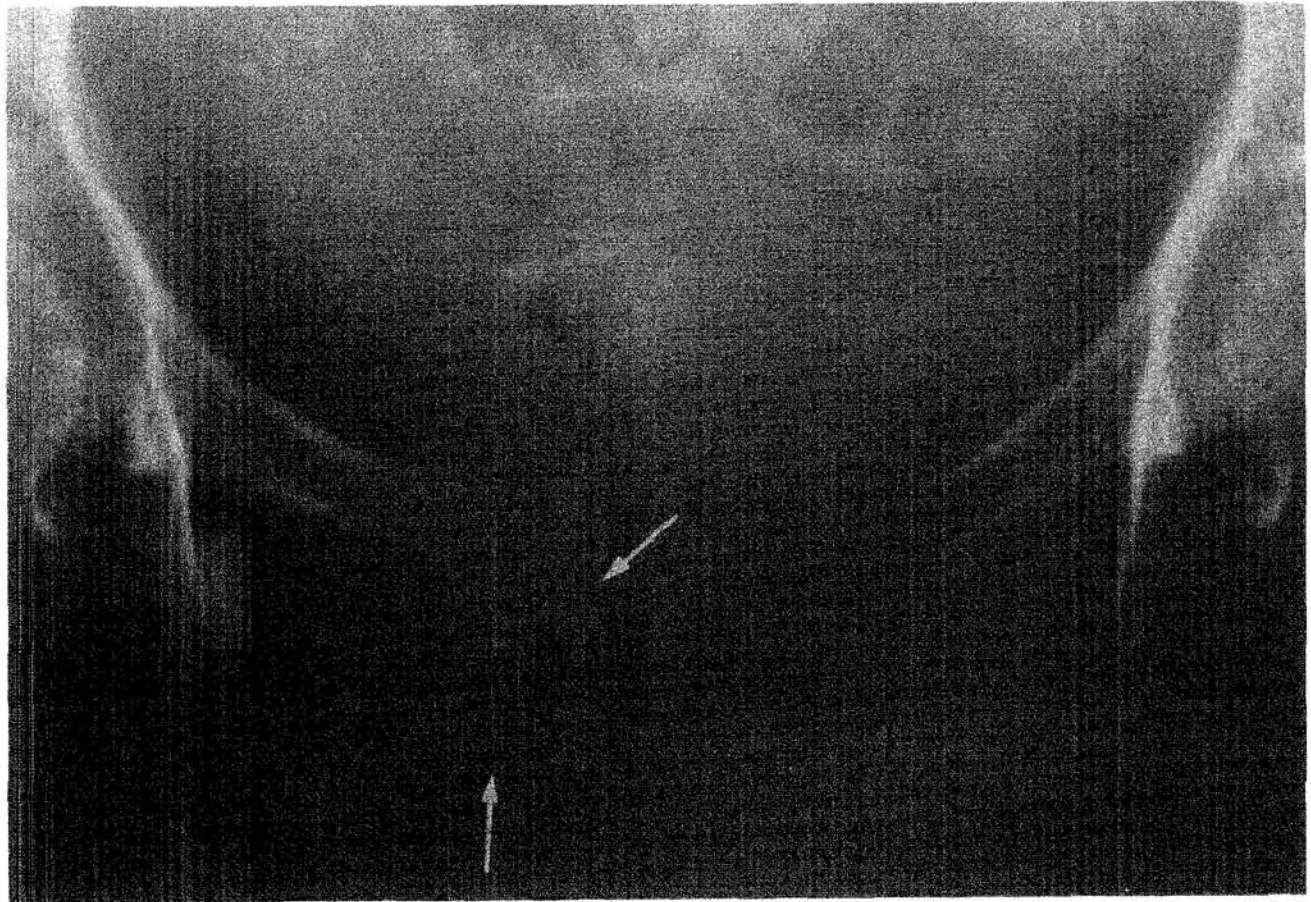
Case 2. Plain radiograph shows a right parasymphyseal linear lytic lesion with surrounding sclerosis (arrows).
